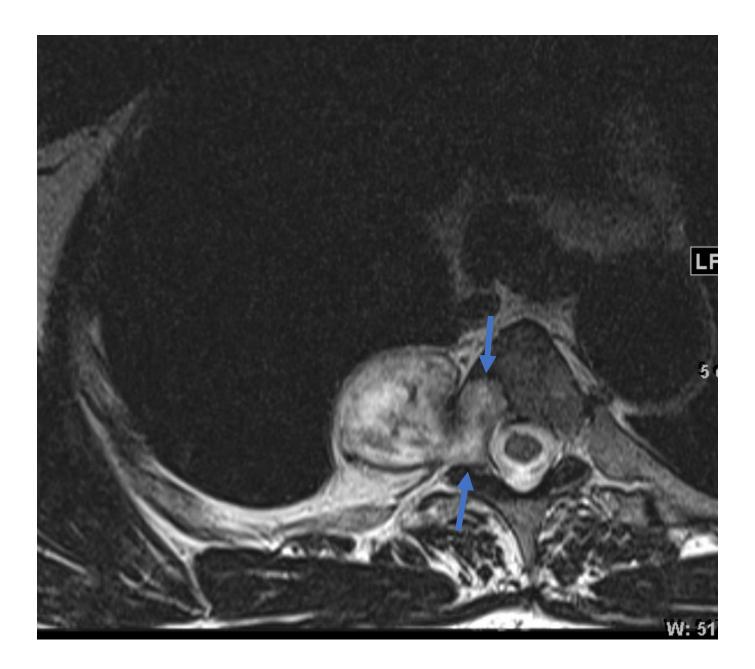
Axial MRI: T2 weighted. Soft tissue lesion (blue arrows) originating from and expanding the neural foramen.
